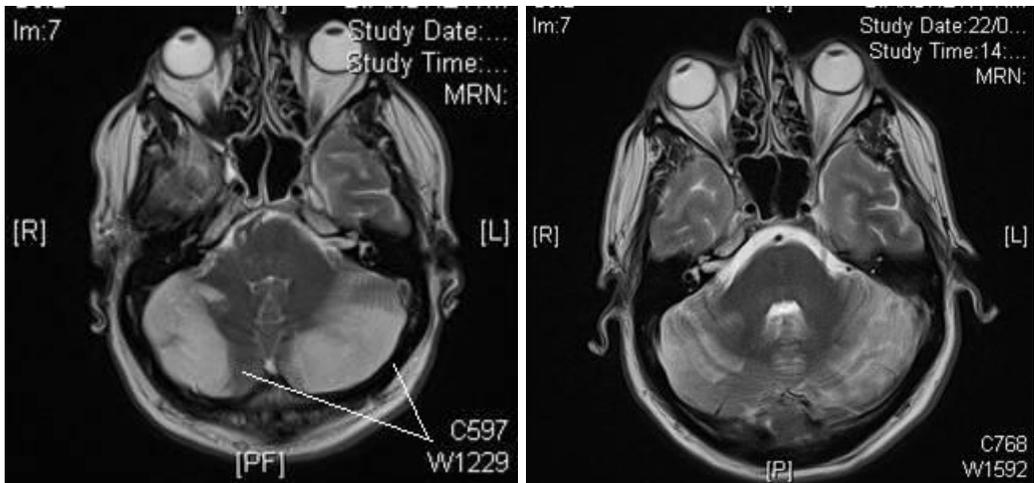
Primary CNS vasculitis. T₂-weighted MRI of the brain shows bilateral cerebellar hemispheric infarcts and abnormal signal hyperintensities before treatment (A) that resolve after immunosuppressant.
